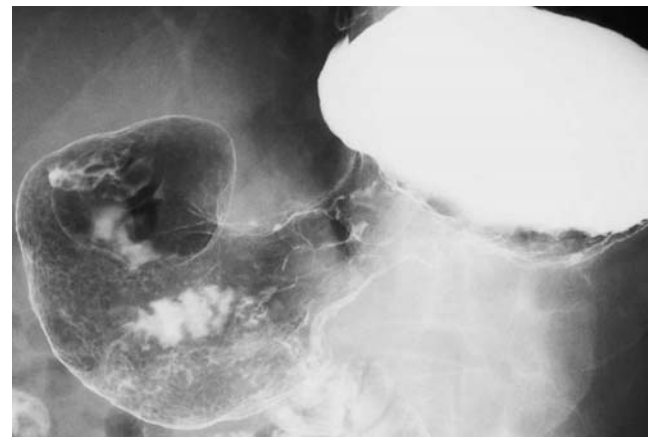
Case 1. X-ray examination performed 1 year and 9 months later, showed the lesion had become a scirrhus gastric cancer
